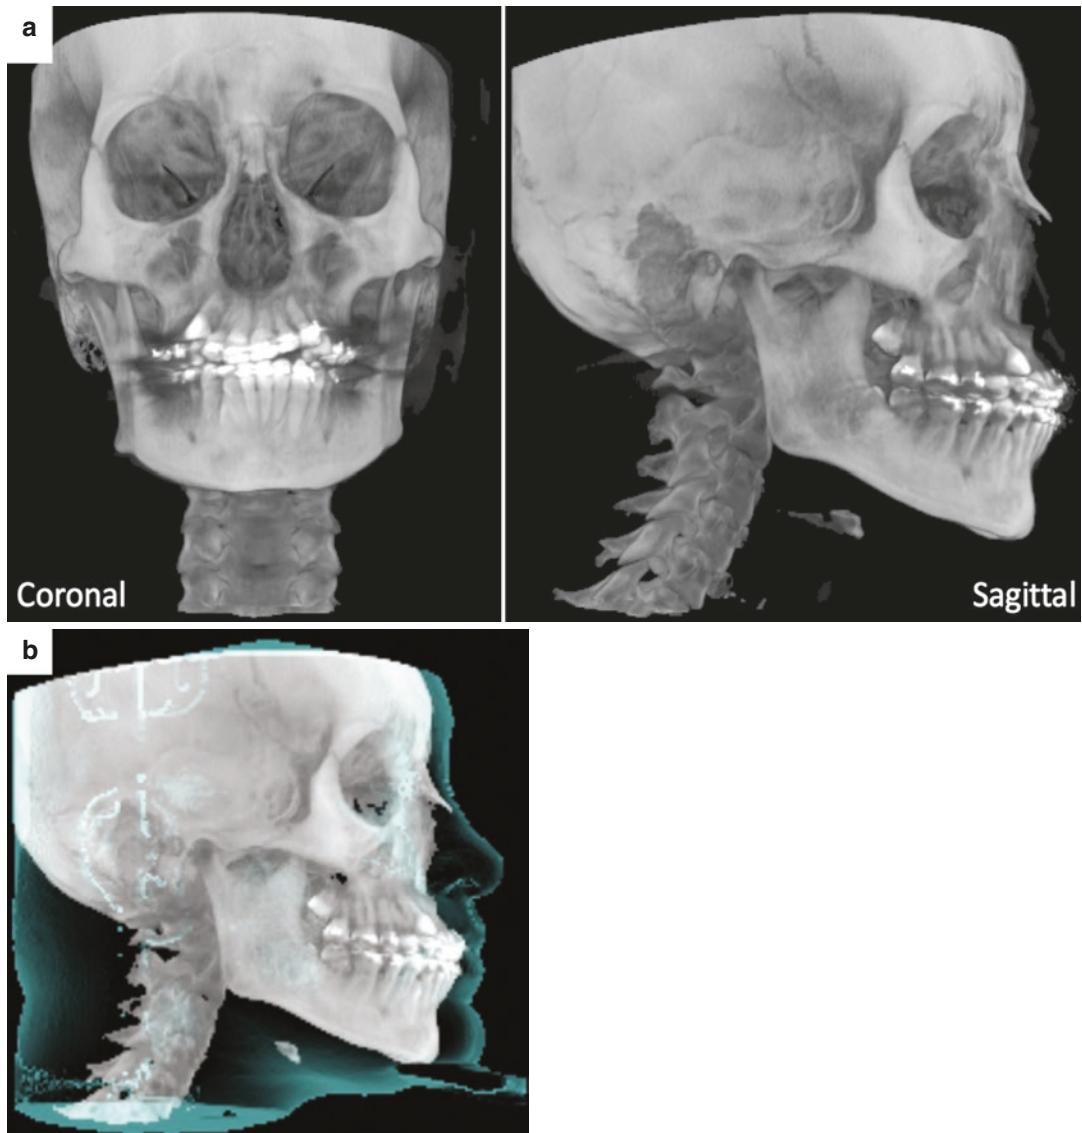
(a) Hard tissue renderings from CBCT data are shown. (b) Example of another type of rendering with soft tissue is shown
